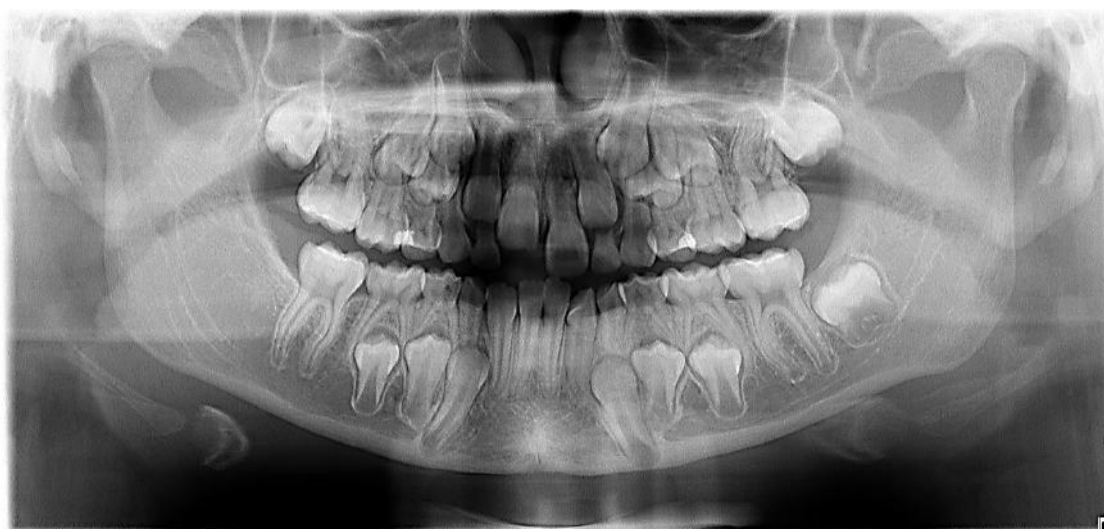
Panoramic radiograph 2 years and 3 months after enucleation and curettage of the lesion.
